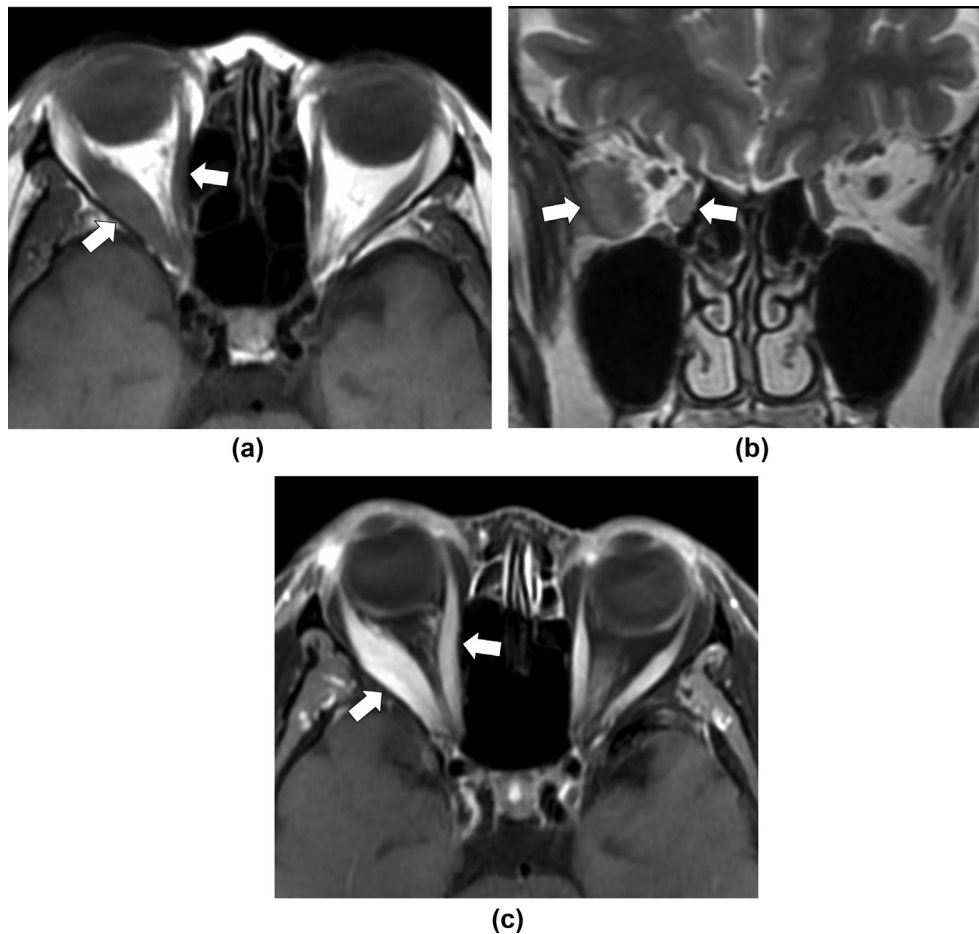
A 60-year-old man with idiopathic orbital inflammatory disease. (a,b) Axial T1-weighted and coronal T2-weighted images show diffuse enlargement of the right lateral and medial rectus muscles (arrows) with uniform intermediate signal intensities. (c) Contrast-enhanced fat-suppressed T1-weighted image shows homogeneous enhancement of the enlarged muscles (arrows).
